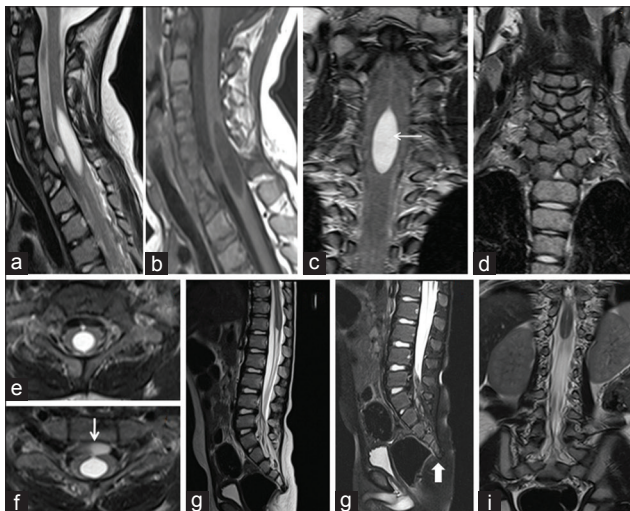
A 5-year-old male child with quadriplegia, (a) sagittal T2-weighted image, (b) T1-weighted image, and (c) coronal T2-weighted images show a T1 hypo- and T2 hyper-intense cyst within cervicodorsal cord (← arrow). (d) Coronal T2-weighted images show segmentation defects in C3 to D1 vertebrae. (e and f) Axial T2-weighted images show smaller cyst in anterior epidural space at C7 vertebral level with a thin communication between the extra- and intra-medullary cysts (↓ arrow). (g) Sagittal T2-weighted images, (h) short-tau inversion recovery, and (i) coronal T2-weighted images show a complete absence of coccyx (↑ block arrow) with conus terminating at the D12 vertebral level, representing Type V caudal regression syndrome.
